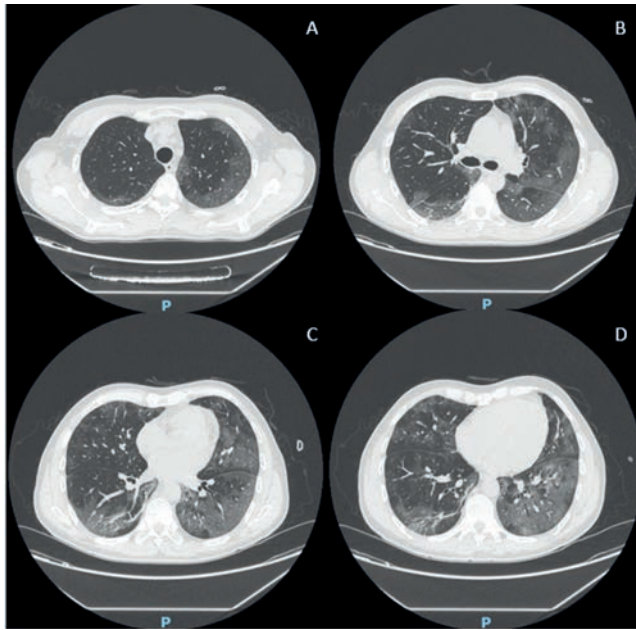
A-D) Computed tomography scan showing mild COVID-19 pneumonia with no bullae.
